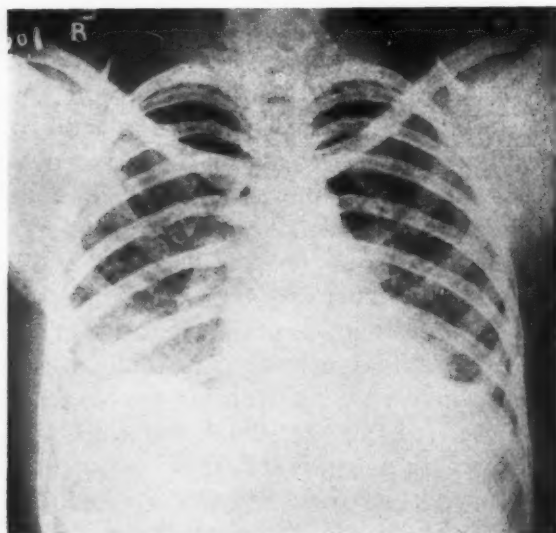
X-ray of the chest of patient M. M., Case I, with generalized scleroderma.
